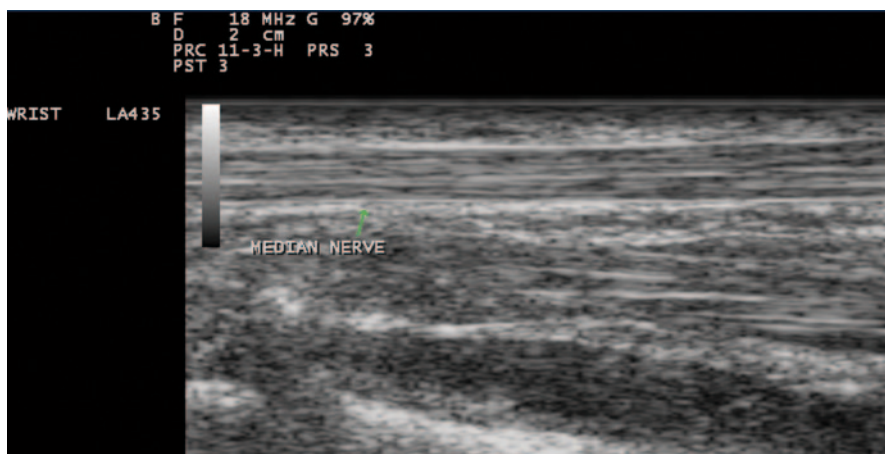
Gray scale US using Esaote Mylab 25 system: Palmar longitudinal view at the proximal carpal tunnel inlet showing the normal sonographic median nerve fascicular pattern which appears as multiple bright reflectors with a hyperechoic border
